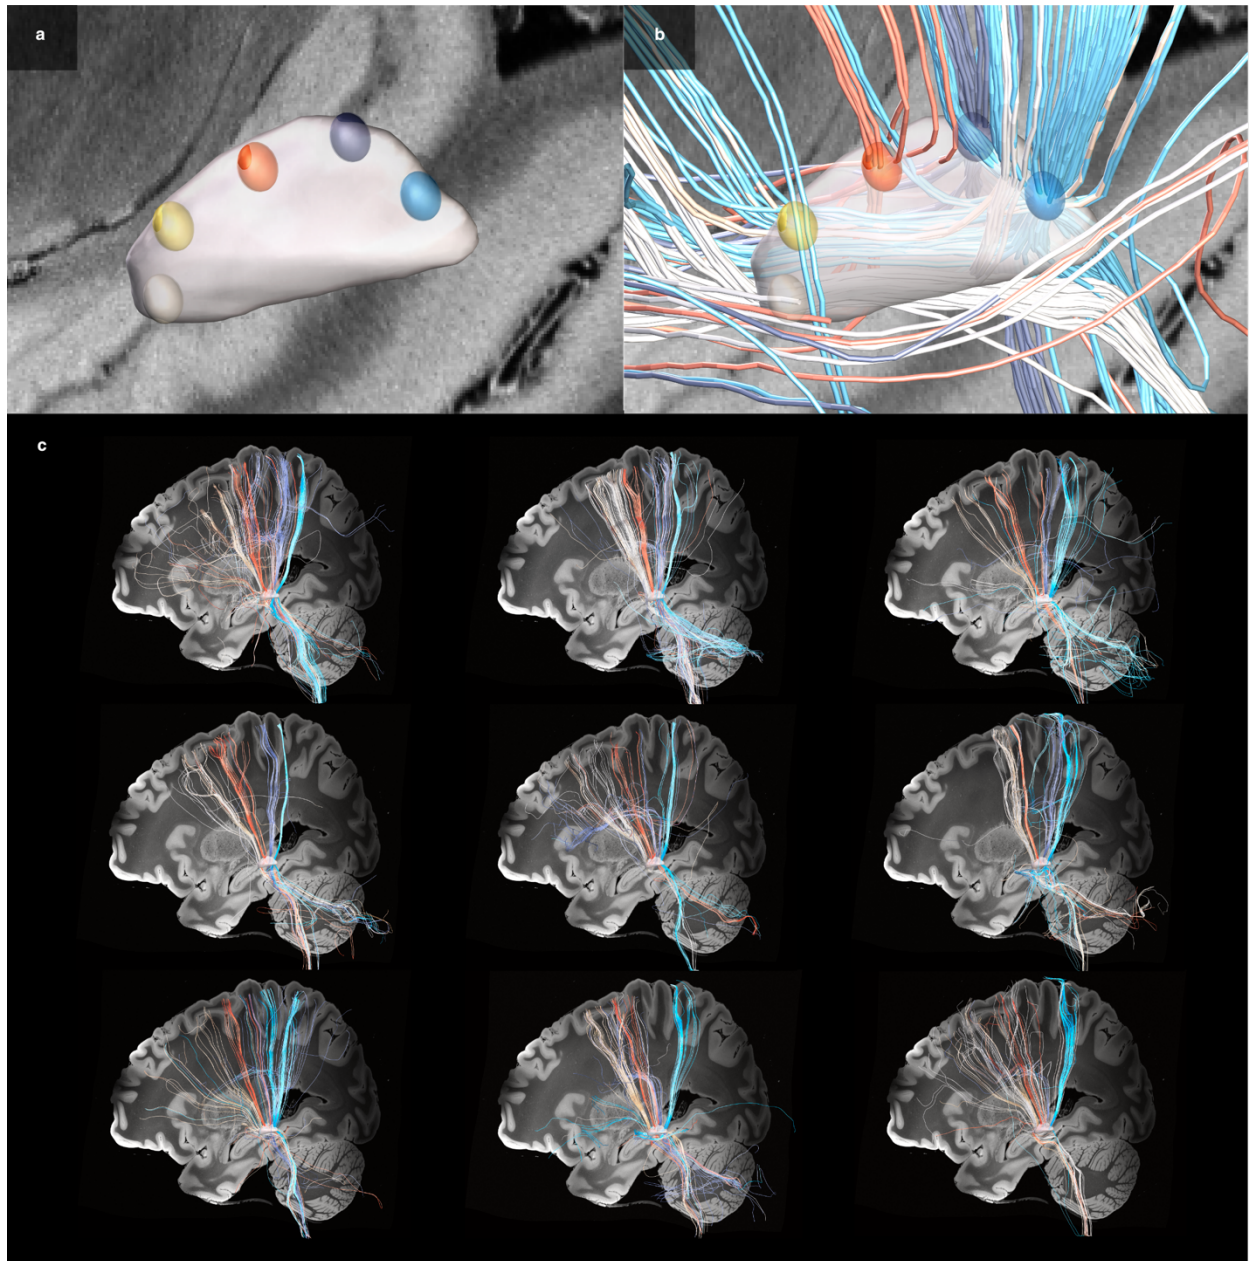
Comparison of the topographical organization of cortico-subthalamic interconnections across individuals. (a) To interrogate the degree of inter-individual variability in cortico-subthalamic anatomical connectivity, five seed points were placed along the dorsal convex shape of the subthalamic nucleus (STN) in standard space, as represented by a three-dimensional model of the left STN from the DBS Intrinsic Template (DISTAL) atlas ¹. (b) Streamlines were tracked from these seed points in nine randomly selected healthy participants of the Human Connectome Project (HCP) ⁶, respectively. To allow for comparison of their anatomical organization, streamlines are tagged with a color that is matched to their respective seed point in panel (a). (c) Despite similarities in the general topographical organization across individual brains, visible differences in the granularities of streamline representations emerged (as discernible in color-coded fashion). Streamline tracking results are displayed against a sagittal slice ($x = -30$ mm) of the 7T MRI ex-vivo 100 μ m human brain template ².
